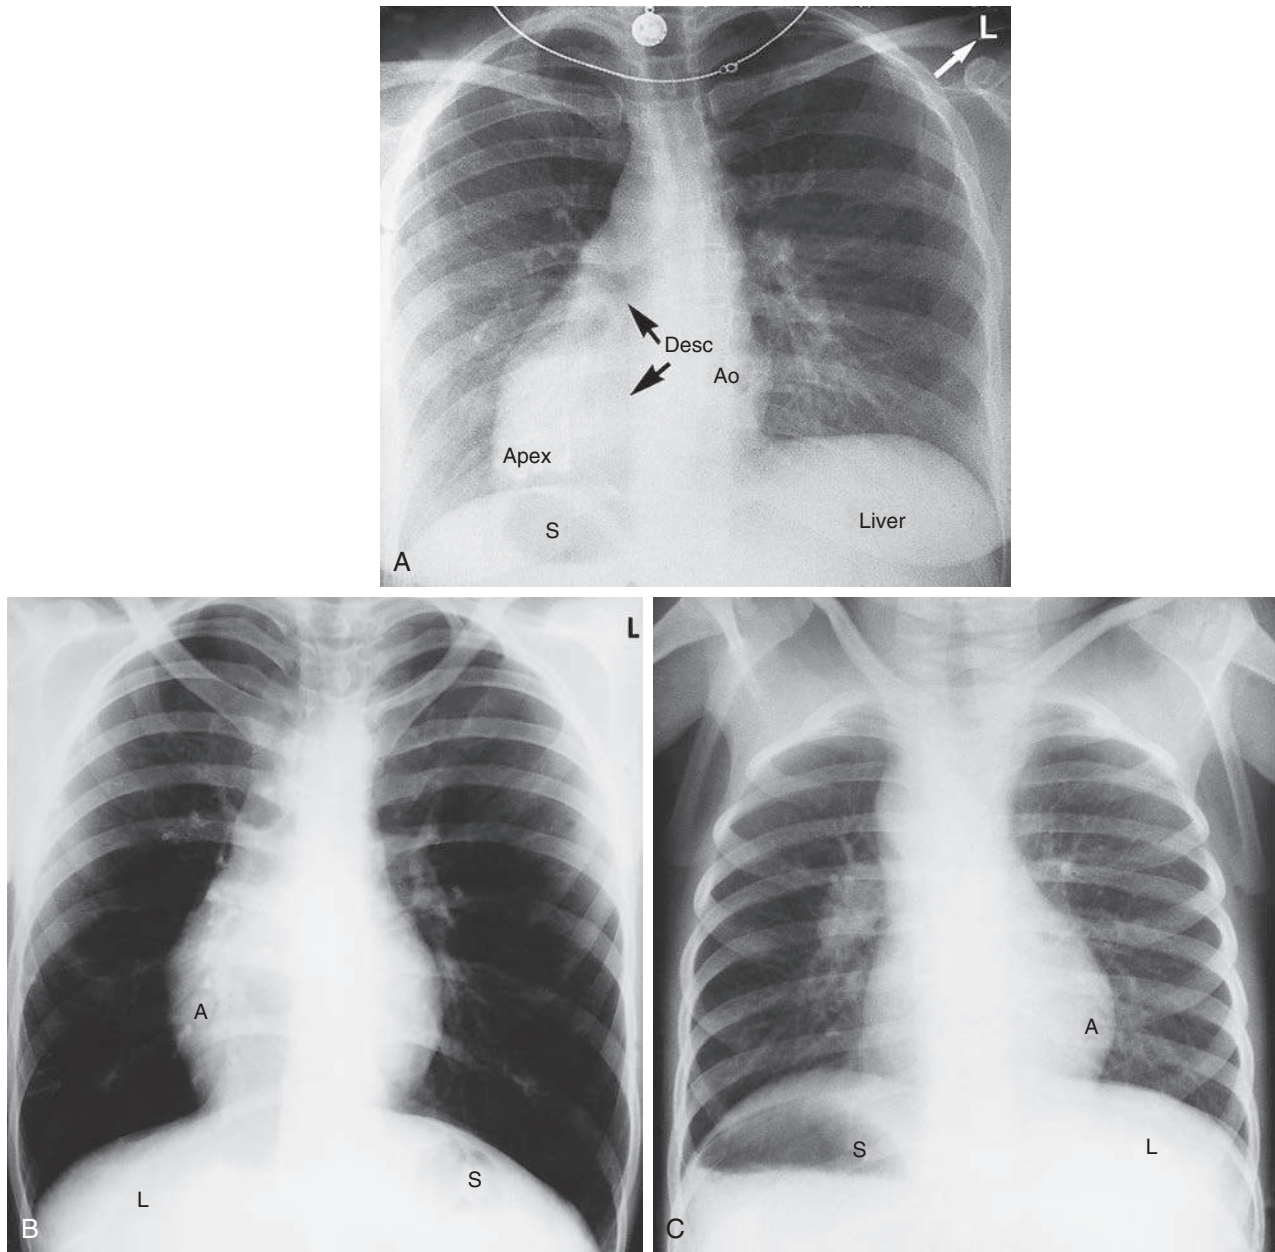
Chest radiographs showing the three basic cardiac malpositions in patients without visceral heterotaxy. A, Situs inversus with dextrocardia (*mirror image*). The liver is on the left, the stomach (S) is on the right, and the cardiac apex is on the right. B, *Situs solitus* with dextrocardia. The liver (L) is on the right, the stomach (S) is on the left, and the cardiac apex (A) is on the right. C, Situs inversus with levocardia. The liver (L) is on the left, the stomach (S) is on the right, and the cardiac apex (A) is on the left. Desc Ao, Descending aorta.
